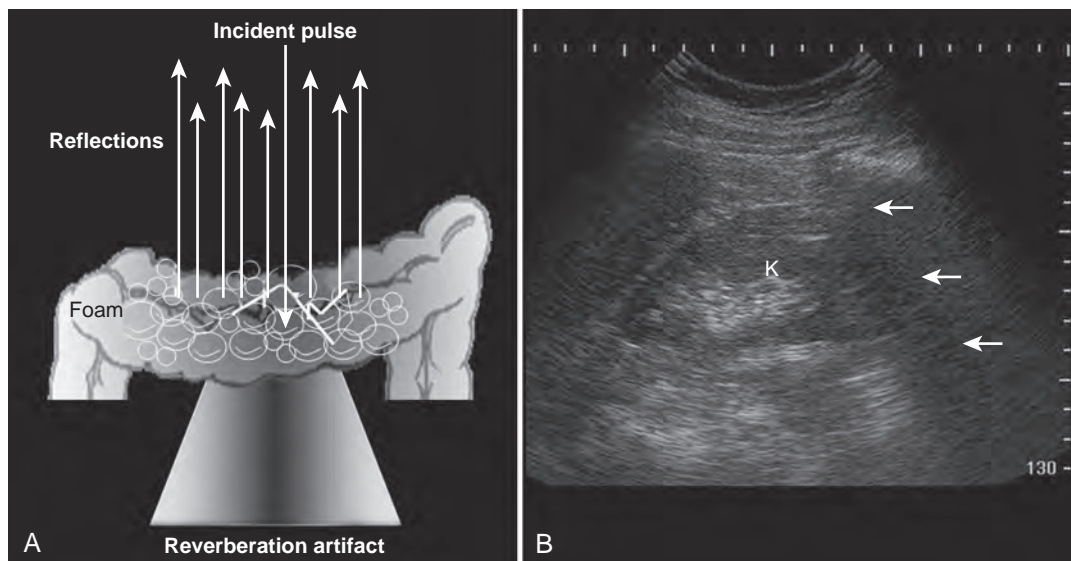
When an ultrasound wave strikes a structure such as bowel, which contains gas bubbles (A), the resultant reverberation artifact has a characteristic appearance sometimes called a “comet tail.” B, A comet tail artifact produced by bowel gas (arrows) obscures the lower pole of the kidney (K).
